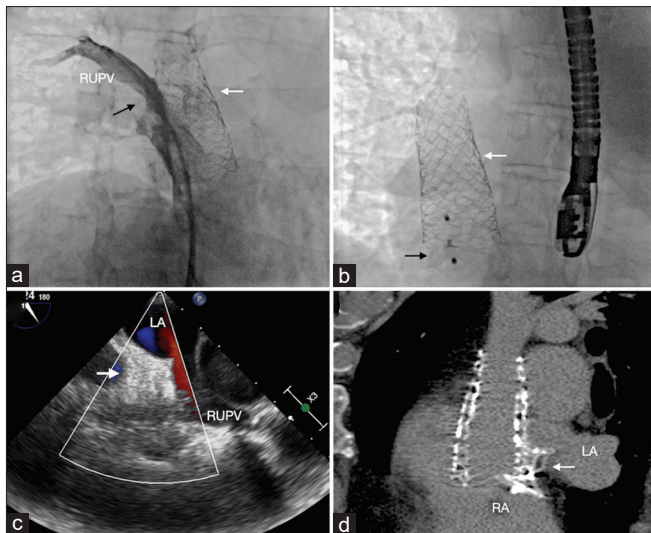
Angiogram from Mullins Sheath (a) across the residual defect (black arrow) into the RUPV shows the residual flow on the right end of the stent (white arrow). Konar MF device (b) across the defect closed the residual flow (c) and demonstrated laminar RUPV flow to the LA on transesophageal echocardiogram. Computed tomography after 6 months (d) shows the device position (arrow) in relation to the covered stent and RA. RA: Right atrium, LA: Left atrium, RUPV: Right upper pulmonary vein. White arrow indicates Konar MF device
